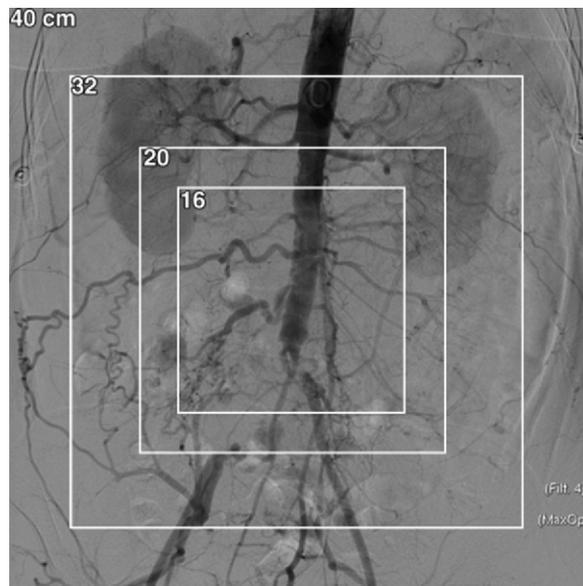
Use of smaller FOVs in an FPD fluoroscopy system. Image obtained with an FPD system shows several possible FOVs. To achieve a smaller FOV, the x-ray collimator blades close to select data from a smaller central portion. These data are then displayed across the entire viewing monitor.
